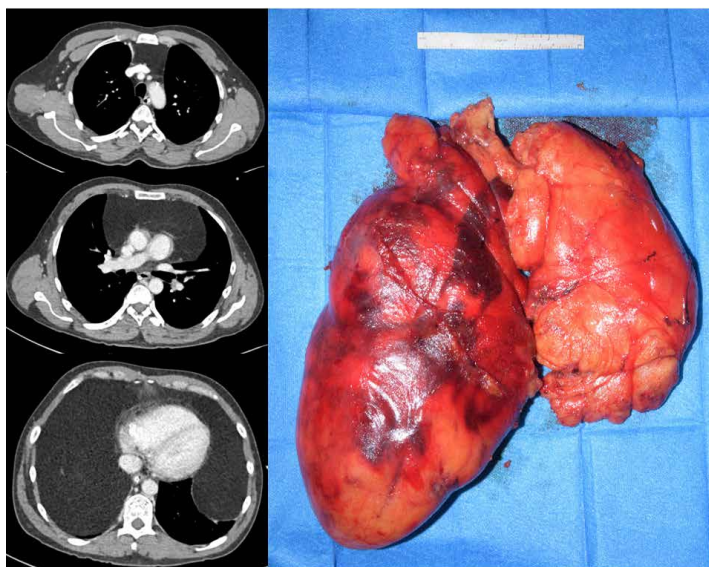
Left: Chest CT scan showing a massive tent-shaped fatty mass originating from the anterior mediastinum reaching into the basal and anterior hemithoraces bilaterally. Right: Mass resected from the anterior mediastinum
